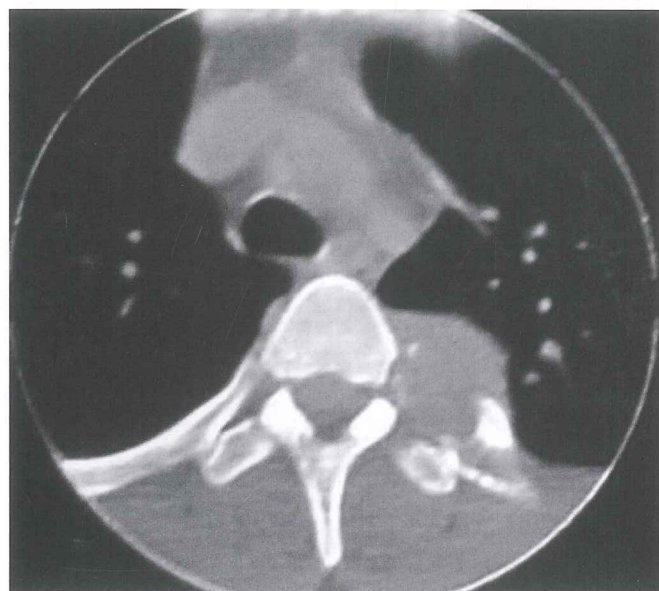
CT scans of thorax showing hypodense, complicated cystic lesions with destruction of fourth rib and transverse joint.
